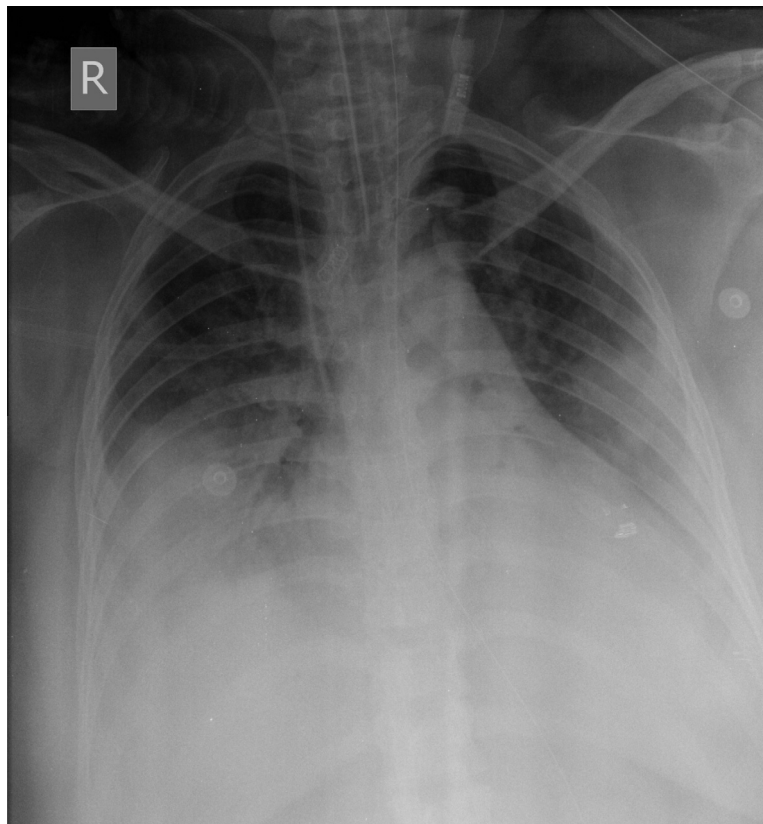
Chest X-ray frontal projection 8 days after admission showing bilateral patches of consolidation mainly within the mid and lower zones. Nasogastric and endotracheal tubes as well as right central venous line are noted.
